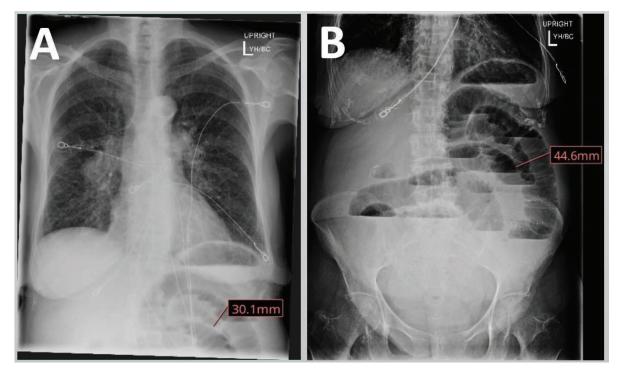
X-ray at Admission. A, XR chest—prominent perihilar marking, interstitial pattern of lung disease, gaseous distention of partial image. B, XR abdomen—small bowel obstruction with multiple air-fluid levels.
